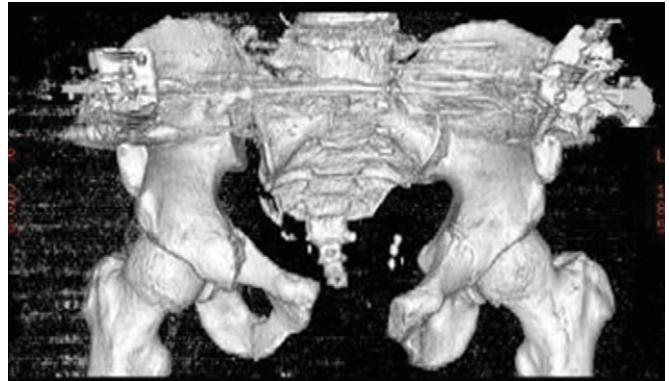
CT reconstruction of a pelvis with an LC type III/Kane type III fracture.
